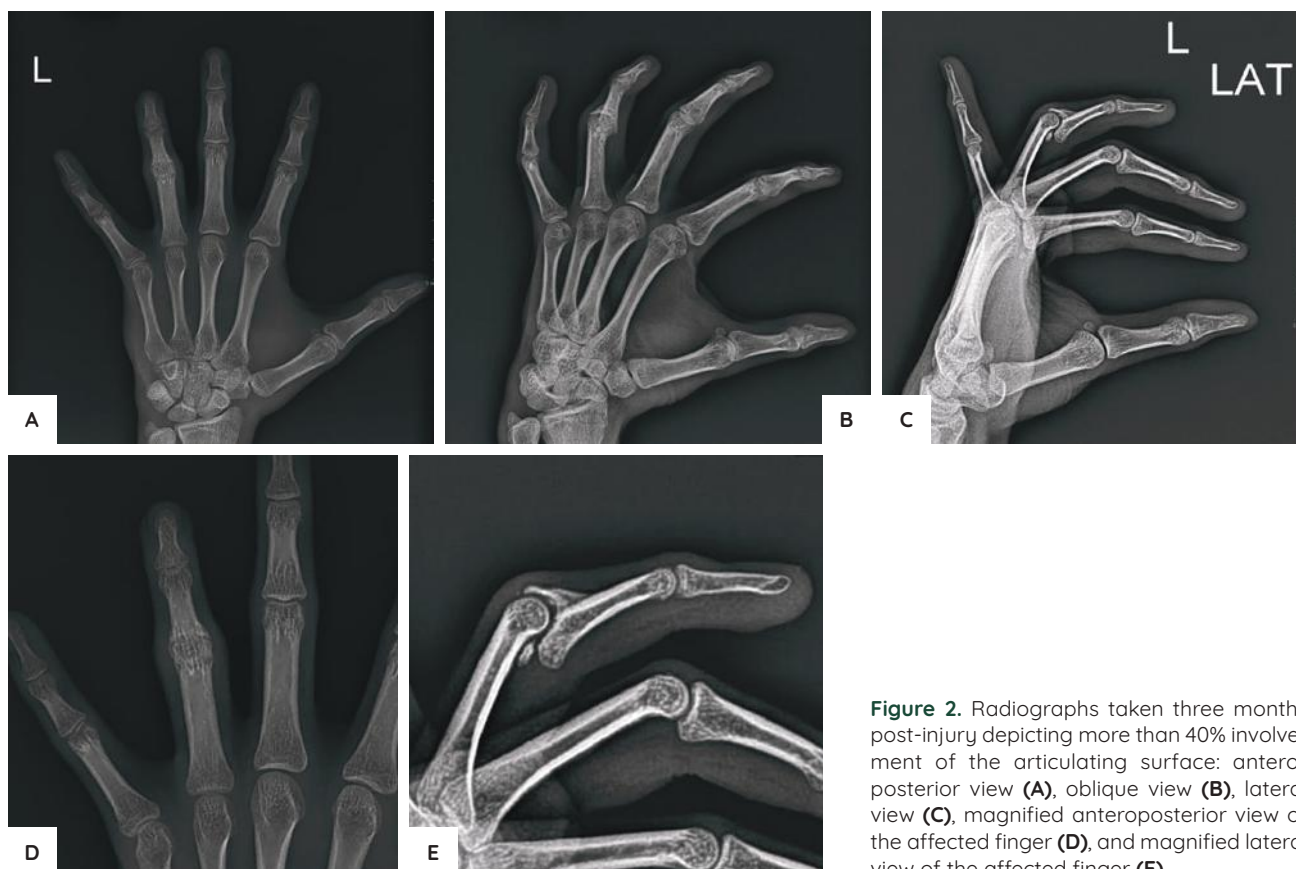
Radiographs taken three months post-injury depicting more than 40% involvement of the articulating surface: anteroposterior view (A), oblique view (B), lateral view (C), magnified anteroposterior view of the affected finger (D), and magnified lateral view of the affected finger (E).
